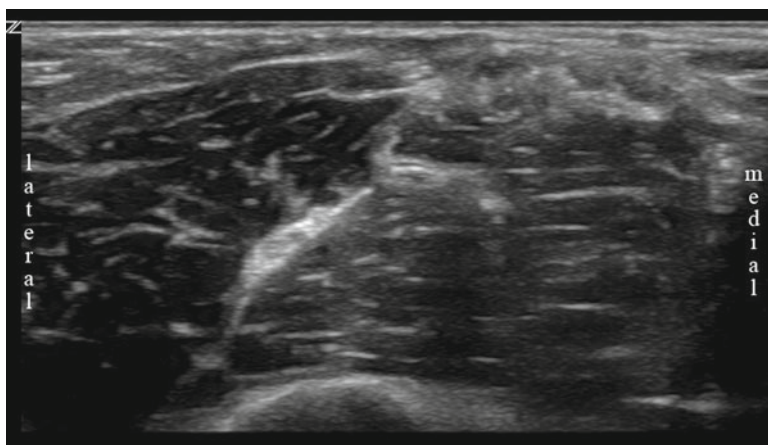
Ultrasonographic appearance of the radial nerve at the elbow
